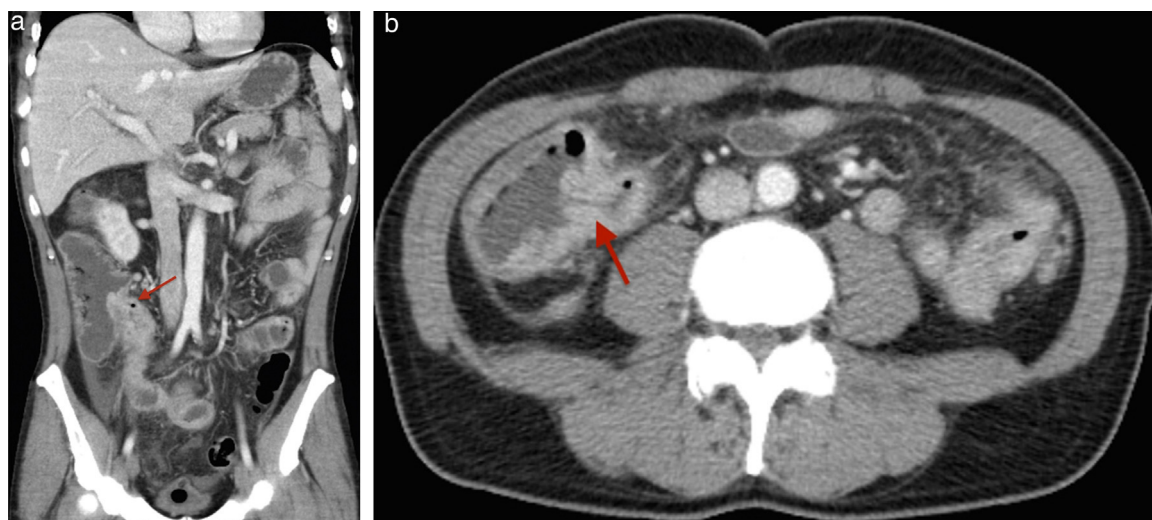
a and b) Abdominal CT images (transversal and coronal views) confirming stricturing lesion adjacent to the ileocecal valve (indicated by the red arrows).
